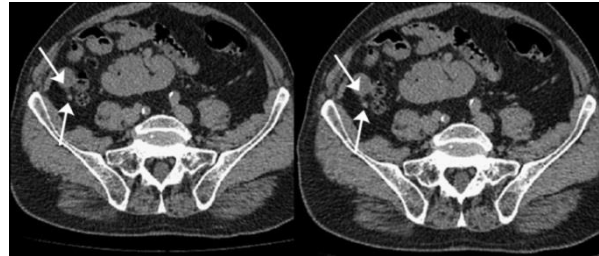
CT coronal reconstructed images of the abdomen showing the right sided appendicitis with the appendicolith (arrows). This subject was in a non-cooperative condition. Small intestine is enhanced instead of colon which is not enhanced.
